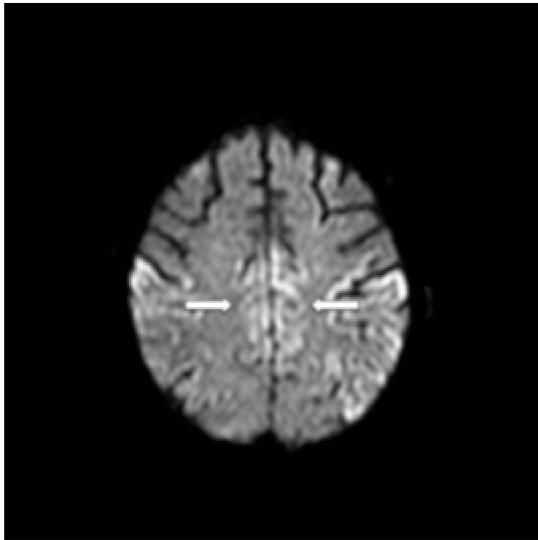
Hyperintense signal in the MRI diffusion-weighted images showing in the cingulate gyrus
